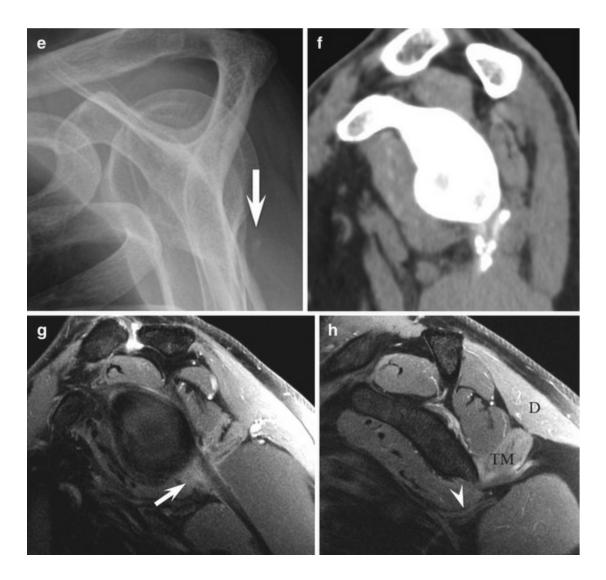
Quadrilateral space syndrome of the left shoulder due to calcific tendonitis of the triceps tendon at the resorptive stage, 2 months after trauma. (a) Photograph of the patient showing atrophy of the deltoid and teres minor muscles. Initial (b) anteroposterior and (c) Y-view radiographs show calcific tendonitis of the supraspinatus tendon and the triceps tendon (arrow). Follow-up (d) anteroposterior and (e) Y-view radiographs 2 months later show a partial resorption of calcium hydroxyapatite deposits of the triceps. (f) Sagittal reformatted CT image shows the calcification affecting the triceps tendon. (g, h) Sagittal fat-suppressed T2-weighted MRI show muscle edema of the teres minor (TM) and deltoid (D) muscles as well as some inflammatory tissue (arrow) affecting the triceps tendon and the upper part of the quadrilateral space. Note the good depiction of the axillary nerve (arrowhead)
